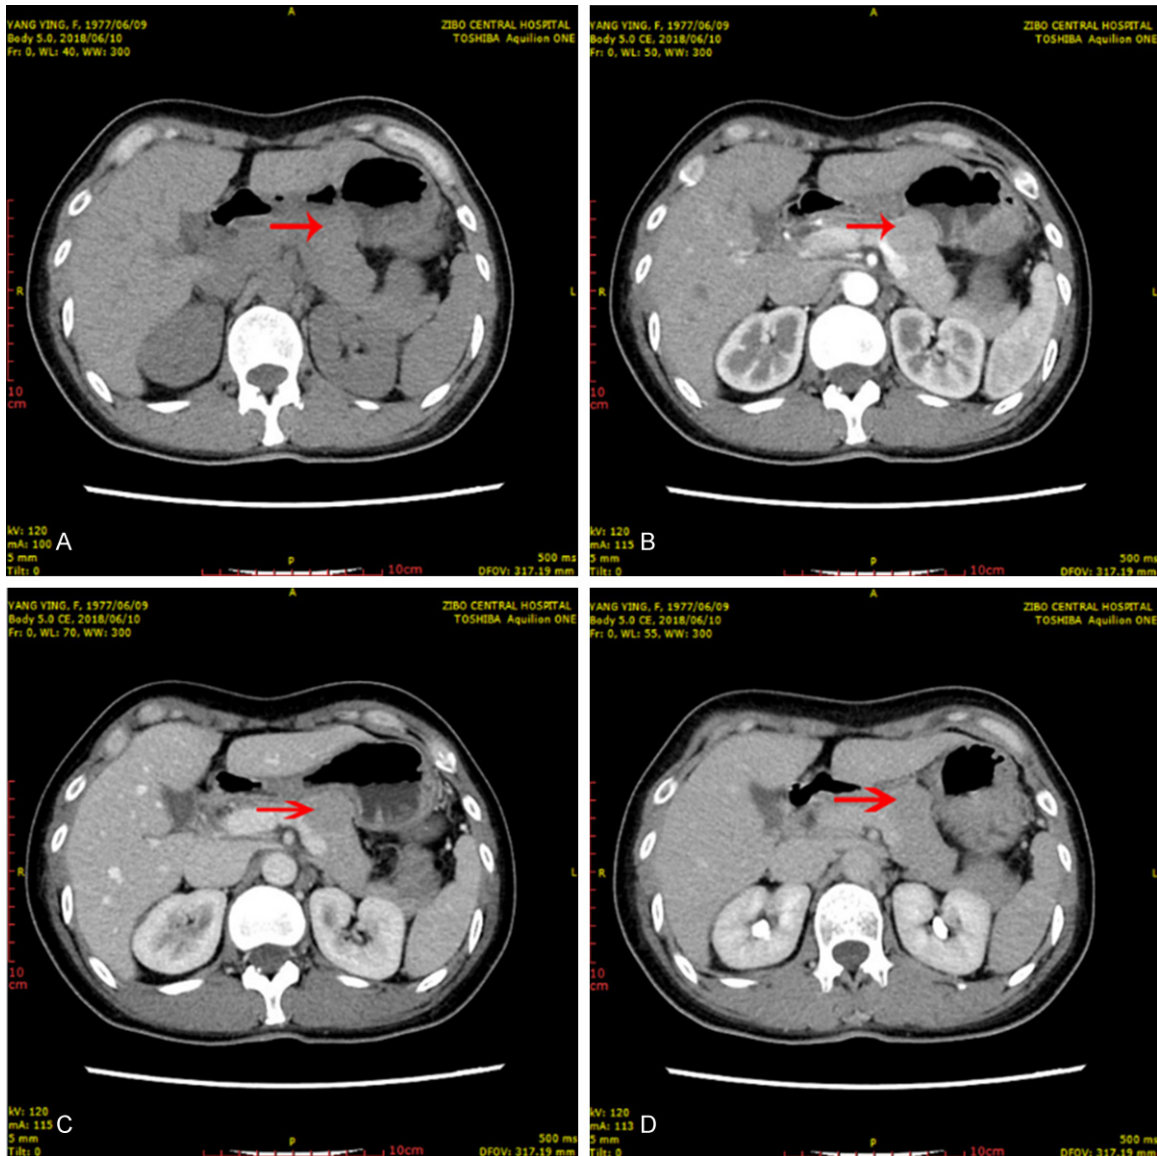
CT revealed a circular isodense shadow in the pancreatic body with rich blood supply and mild protrusion. Contrast-enhanced CT scan revealed moderately progressive enhancement and solid pseudopapillary tumor was suspected. A. CT scan showed an isodense shadow. B. Arterial phase showed the tumor density was lower than that of the pancreatic parenchyma. C. Venous phase. D. The delayed phase showed that the tumor density was almost equivalent to the pancreas density. (Red arrow)
